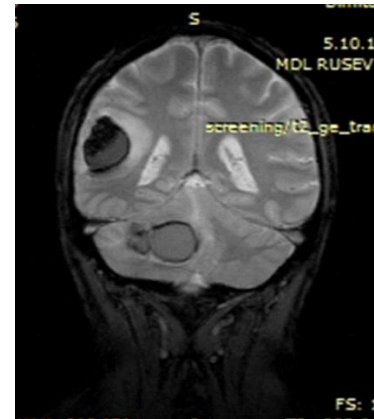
MRI of supratentorial and subtentorial metastases.
